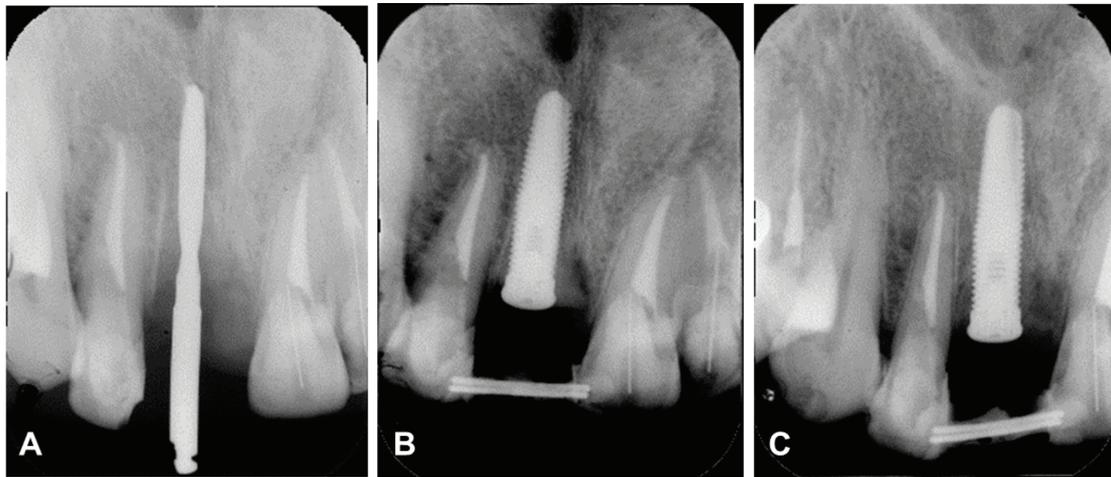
A and B: atraumatic extraction and immediate implant placement into the incisor socket, and C: three months postoperative radiographic control
